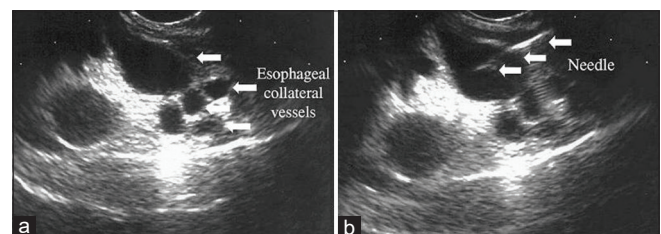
Endoscopic ultrasound-guided sclerotherapy. (a) Endoscopic ultrasound image showing esophageal collateral vessels (arrows); (b) endoscopic ultrasound-guided sclerotherapy for esophageal varices (arrows indicate needle location) (reprinted with permission from Elsevier)
